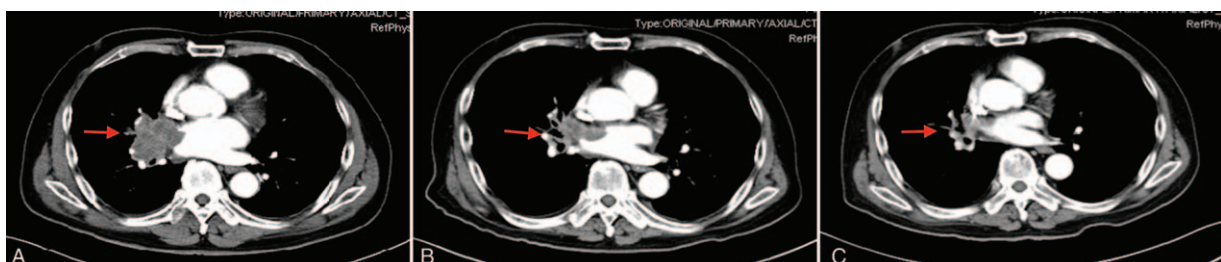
(A) The baseline of chest computed tomography scans revealed a mass in the right middle lung lobe. (B and C) The targeted lesions in the right lung obtained a great cumulative tumor shrinkage after crizotinib therapy.
